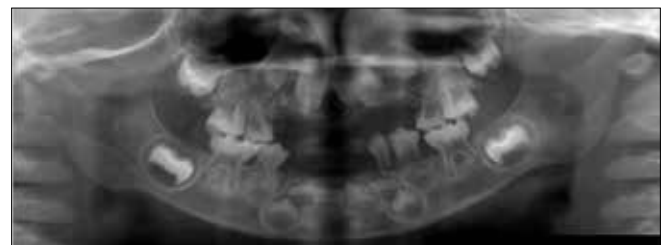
Panoramic radiograph taken at 36 months. Root formation of mandibular primary second molars, which had erupted after initiation of enzyme replacement therapy, was recognized.
